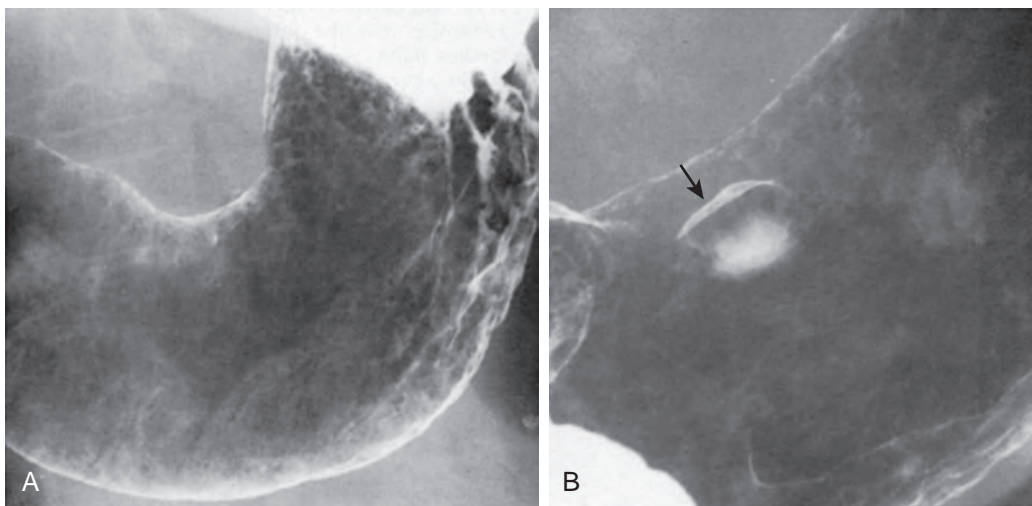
Risk of suboptimal coating. A. On the initial radiograph, an ulcer crater is barely recognizable along the lesser curvature of the stomach. B. With additional rotation and improved coating, the large ulcer crater (arrow) is clearly seen.
